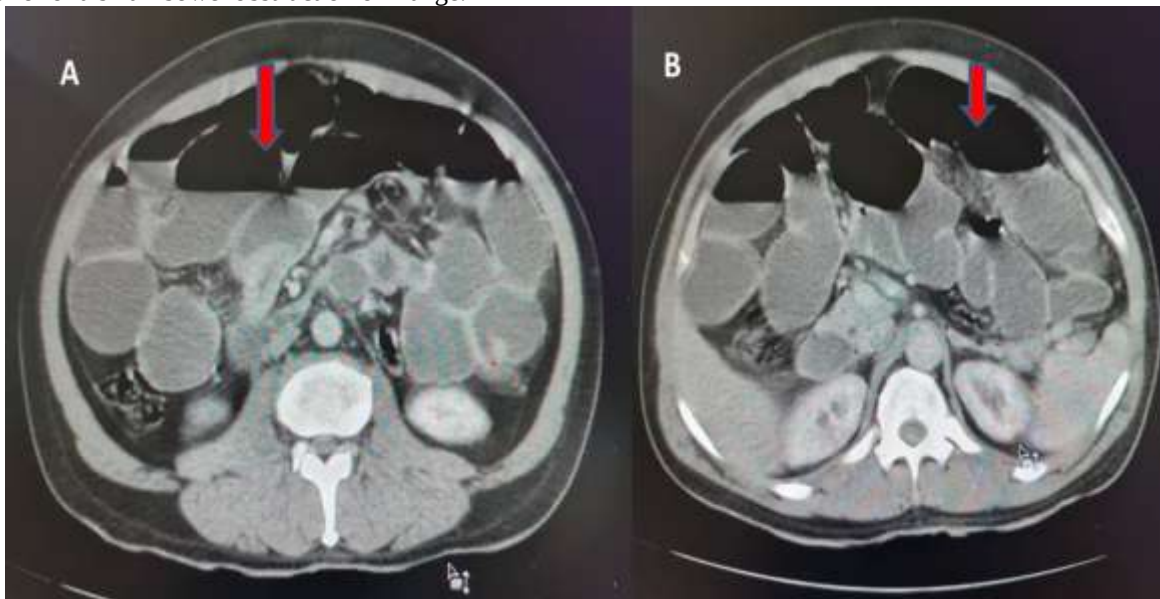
(A and B) Abdominal CT in axial reconstruction after injection of PDC shows dilation of the small bowel loops located at the hydro-aeric level evoking an intestinal obstruction.
